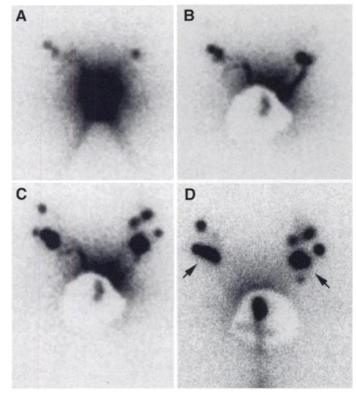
Lymphoscintigram of Patient 4 with a T_2 turnor on the right side of the clitoris. Graphs were selected from a dynamic series. A and B were recorded 5 and 10 min after administration of tracer, without (A) and with (B) shielding of the primary turnor. On the right side two sentinel nodes are shown and on the left side one sentinel node is shown. C and D were recorded 30 and 150 min after administration of tracer. Overflow to nonsentinel nodes is clearly visible on both sides. The arrows in D point to the nodes that were regarded as sentinel nodes.
